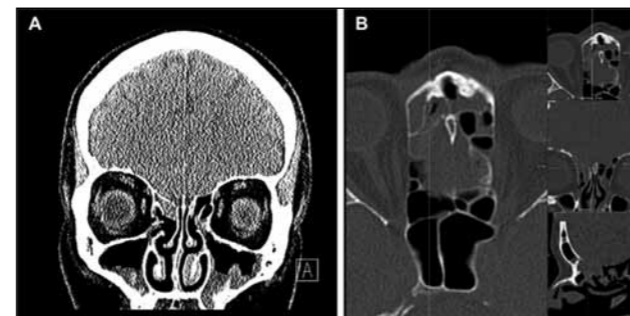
Coronal (A) and cockpit view (B) CT scan demonstrating a right ethmoidal mucosal melanoma, with invasion through the skull base lateral to the cribriform plate.
